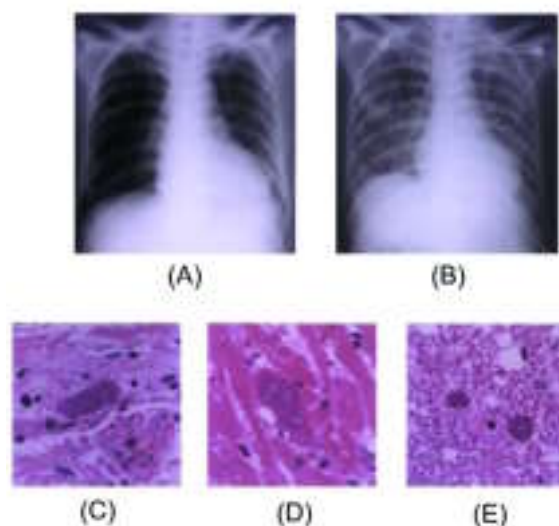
(A) Plain chest X-ray at the onset of respiratory symptoms demonstrated diffuse micronodular and reticular opacities. (B) Chest X-ray, taken 24h later, showed severe bilateral pulmonary infiltration. Multiple cysts of *Toxoplasma gondii* were detected in several organs including the lungs (C), heart (D), and spinal cord (E) at post-mortem examination, suggesting disseminated toxoplasmosis.
